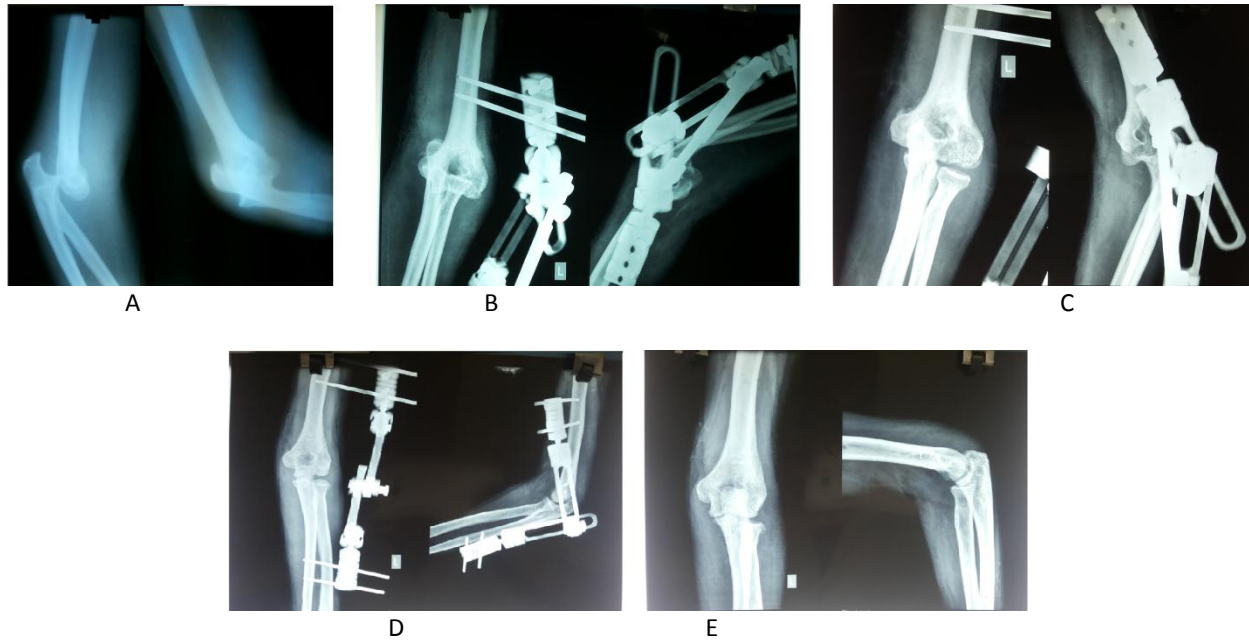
A-E—Anteroposterior and lateral radiographs of Patient 2 treated with Limb Reconstruction System (LRS) showing good reduction of elbow joint at 4 months followupupupup
